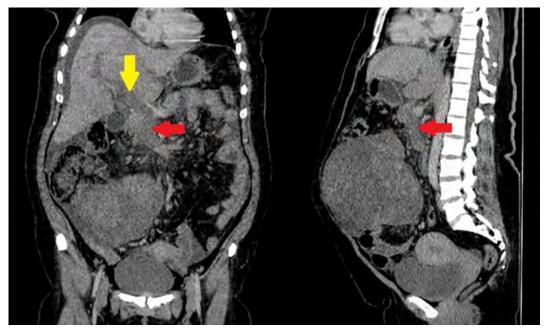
Preoperative contrast-enhanced computed tomography shows prominent thrombus in the portal vein (yellow arrow) and superior mesenteric vein (red arrow).
